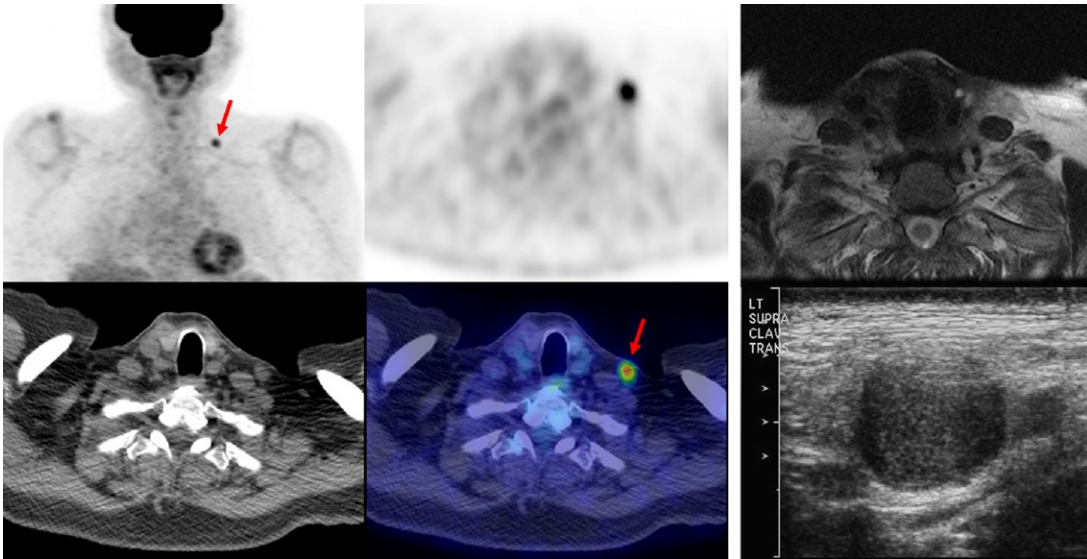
Images of different imaging modalities. (A) Upper left: PET frontal; (B) upper middle: PET transverse; (C) upper right: MRI transverse; (D) bottom left: CT transverse; (E) bottom middle: PET/CT transverse fused image; and (F) bottom right: ultrasound. Images of a 74-year-old male patient with nasal cavity esthesioneuroblastoma (a form of nasal cancer) who was restaged on a routine follow-up. PET identified a left supraclavicular hypermetabolic nodal metastases (A, B, D, and E) that was not identified in the MRI (C). An ultrasound-guided biopsy of the node was positive for esthesioneuroblastoma and then surgically resected (F). *Courtesy of Dr. Rathan Subramaniam, 2010.*
